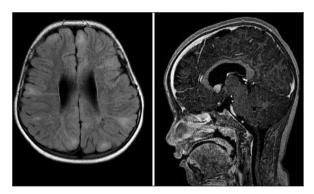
A) Axial magnetic resonance imaging (MRI) of the brain B) demonstrating multiple tubers in both hemispheres. Sagittal MRI demonstrating subependymal giant cell astrocytoma at typically intraventricular location.
